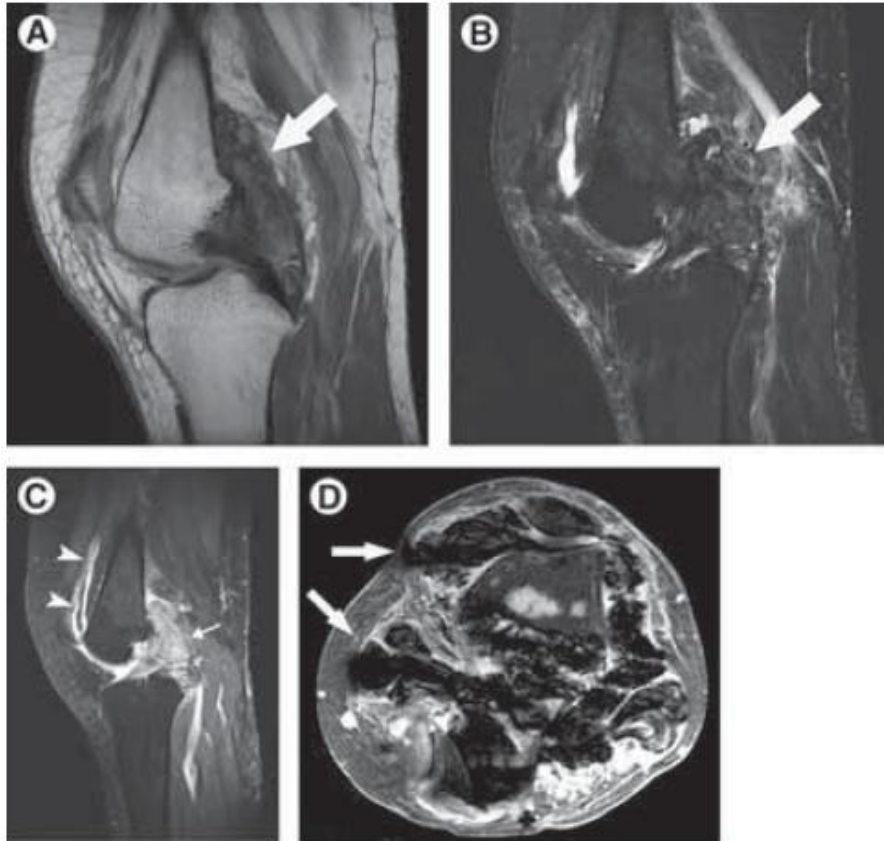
Diffuse PVNS. A 68-year-old white female with a history of knee pain and swelling. (A) Sagittal proton density-weighted (TR/TE; 2000/18). (B) T2-weighted image with fat saturation (TR/TE; 3000/70) and (C) T1-weighted fat saturation postcontrast images (TR/TE; 550/18) show a heterogeneous lesion filling the posterior knee joint (arrows) with intermediate to decreased signal. Postcontrast image demonstrates diffuse enhancement of the lesion (small arrow) and synovitis in the suprapatellar bursa (arrowheads). A 36-year-old woman with knee pain and swelling shows (D) a large intra-articular lesion with "blooming" artifact (arrows) on gradient echo sequence (TR/TE; 58.2/05).
